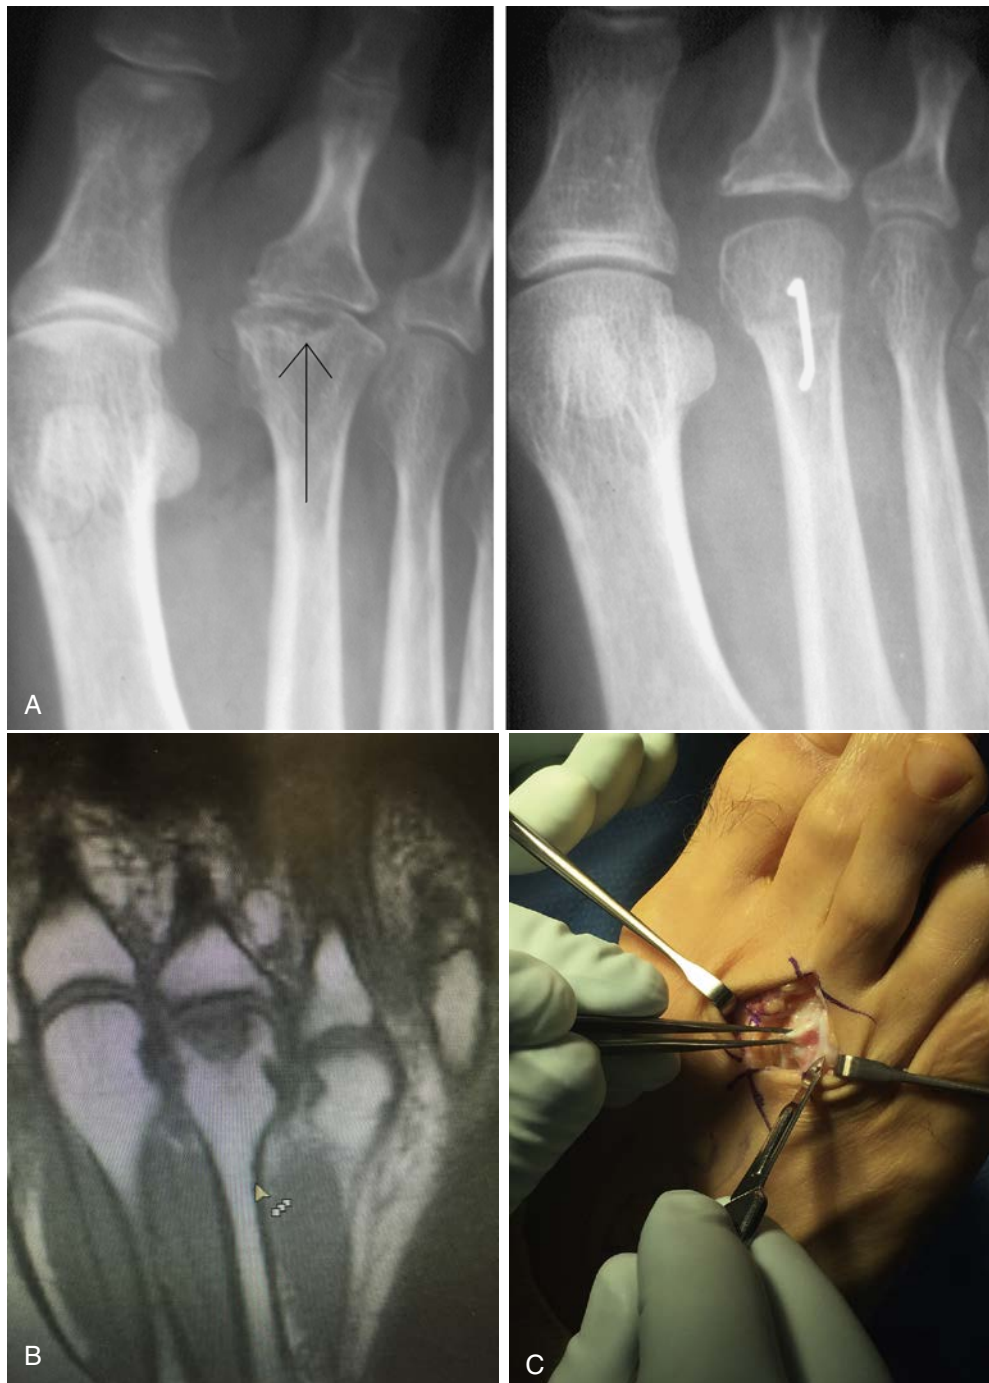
Freiberg's Infraction. (A) Preoperative and postoperative anterior-posterior radiographs of the second metatarsal Freiberg's infraction; (B) transverse T1 magnetic resonance image of a third metatarsal Freiberg's infraction; (C) intraoperative findings with cartilage delamination.
